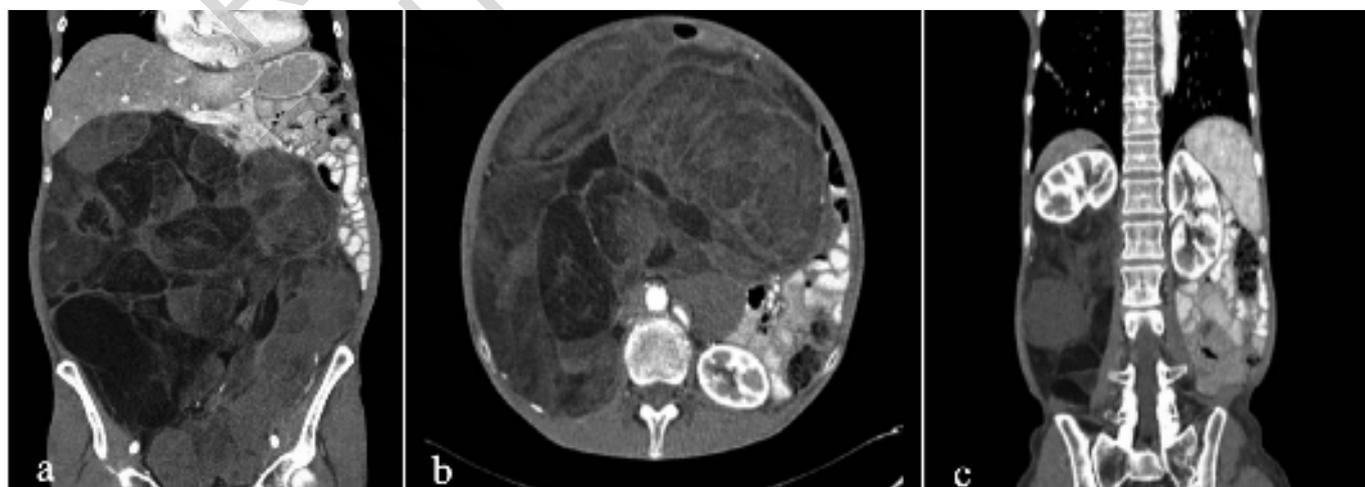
A,C) Coronal and B) axial preoperative contrast-enhanced abdominal computed tomography scan showing the giant retroperitoneal liposarcoma going from the subhepatic region to the pelvic cavity (40cm x 30cm) displacing and rotating the right kidney to the diaphragm.
